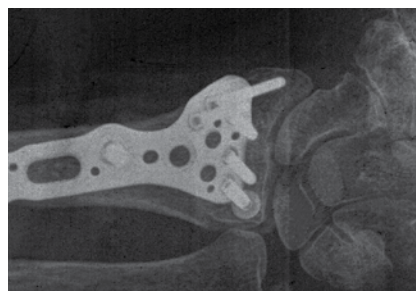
6 Week Post-Op X-ray
